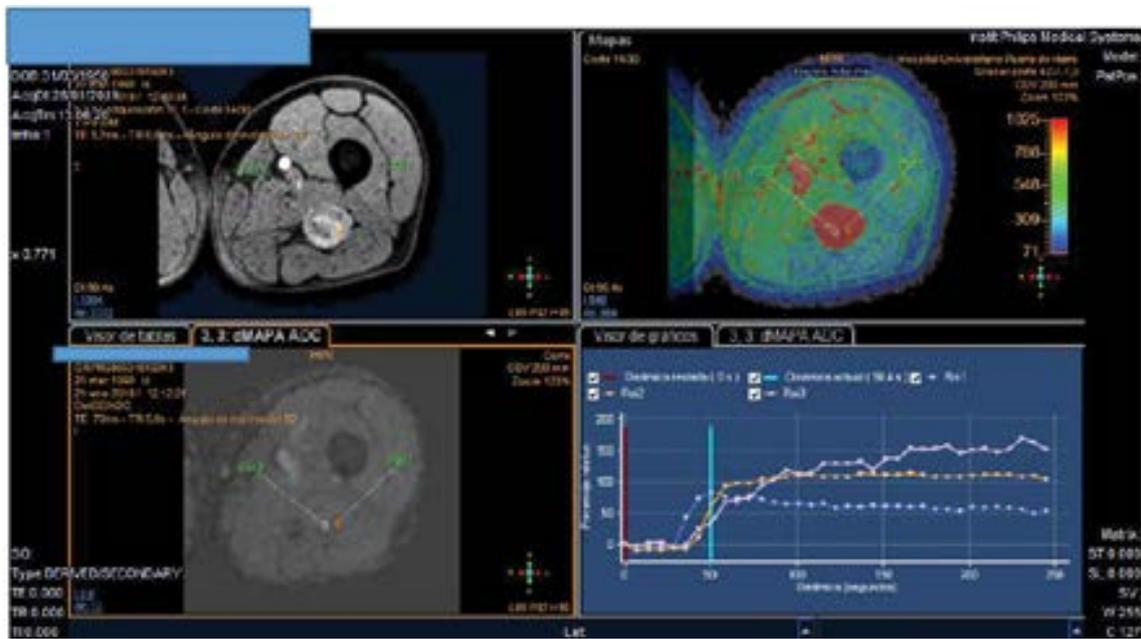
MRI of a soft tissue tumour.
